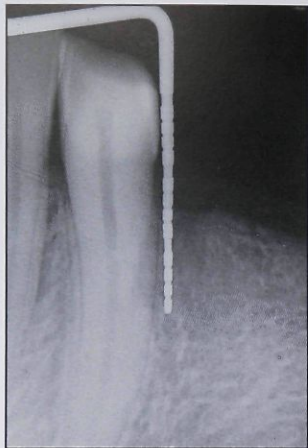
Preoperative radiograph showing a significant intrabony lesion. A Michigan O probe is placed to the base of the intrabony defect. Pocket depth is 11 mm.
